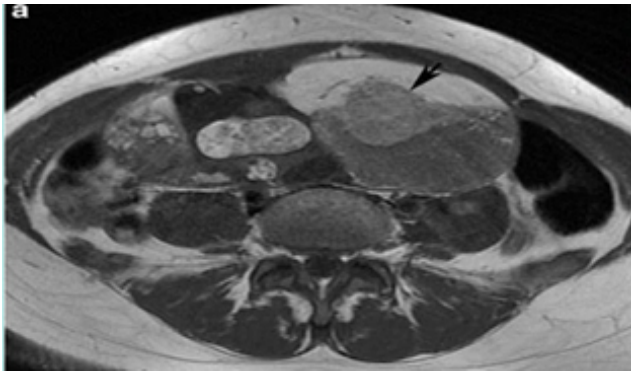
T1W1 MRI sequence showing well defined cystic lesion
